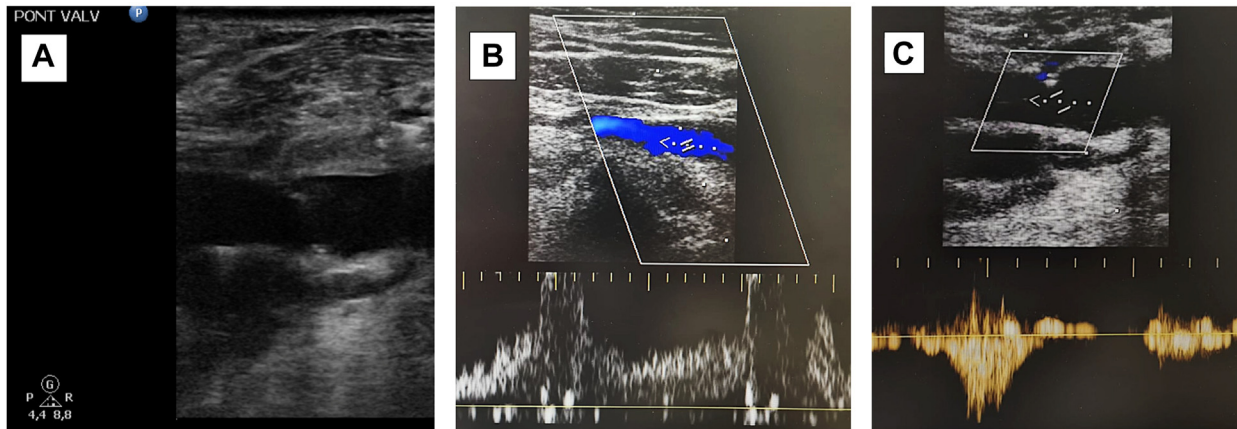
(A) Ultrasound sagittal view of the venous bypass visualizing the transposed valve. (B) Doppler ultrasound showing the axillary venous graft patency. (C) Valvular continence during a Valsalva maneuver.
